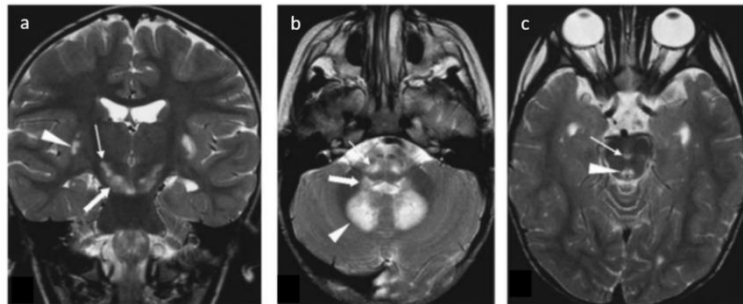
Magnetic resonance imaging of a LS patient
